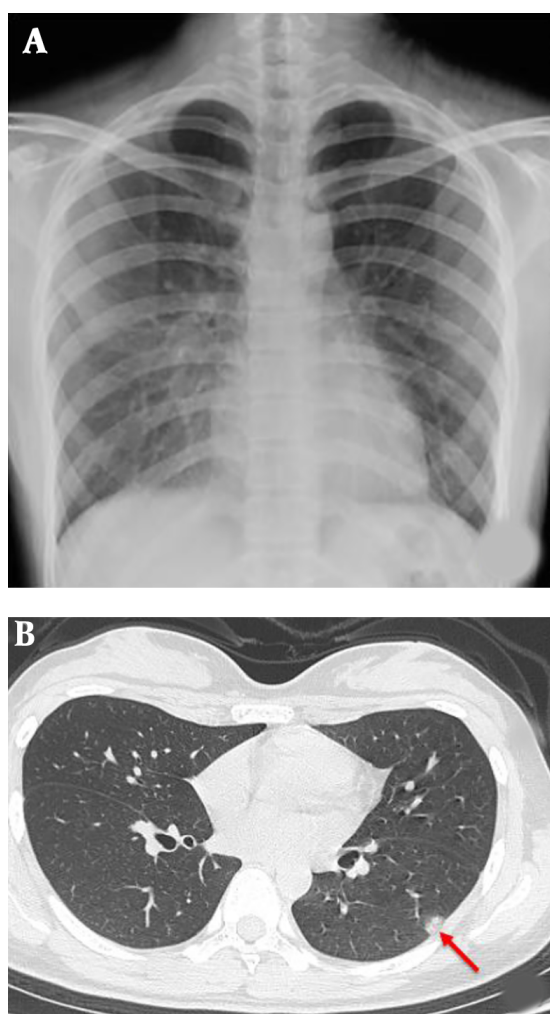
Female, 24 years old, come from Wuhan city, without clinical symptoms (have a fever after 2 days). No obvious abnormality was found in chest X-ray (A). Solid nodule of the left lower lobe with halo sign in chest CT (B). (window level-600, window width-1600).
